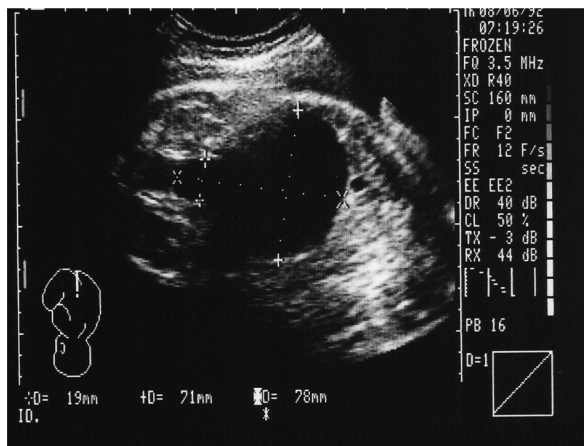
Prenatal ultrasound at 36 weeks gestation. A complete structural ultrasound evaluation was performed by a trained ultrasonographer that revealed an enlarged bladder (71 mm in sagittal length) with failure to empty over at least 53 min, which is greater than the 45 min generally accepted as the upper limit of normal<sup>3,10</sup>. The scan shows the keyhole sign, representing dilatation of the posterior urethra. The sagittal length is 78 mm, which is greater than gestational age (in weeks) + 12 (upper limit of the 95% confidence interval).
